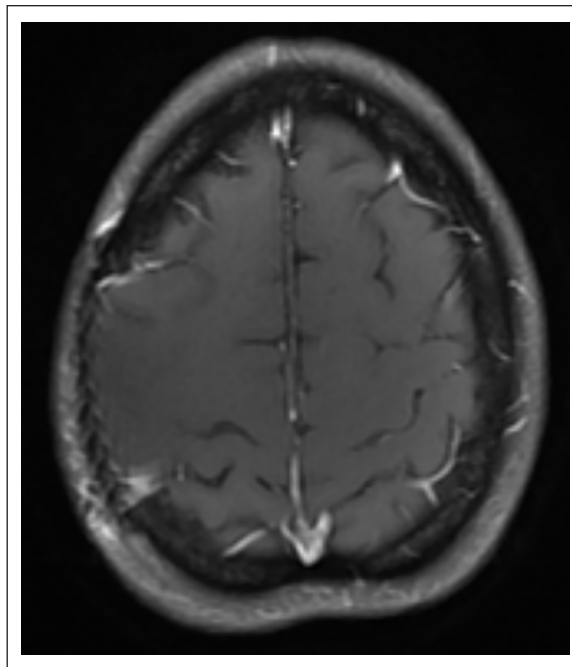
Imaging: MRI axial T1 post-op. Axial T1-weighted post-contrast image, from 15/7/2015, shows postsurgical changes related to a right frontoparietal cranioplasty, without evidence of nodular enhancement to suggest residual or recurrent tumor.
